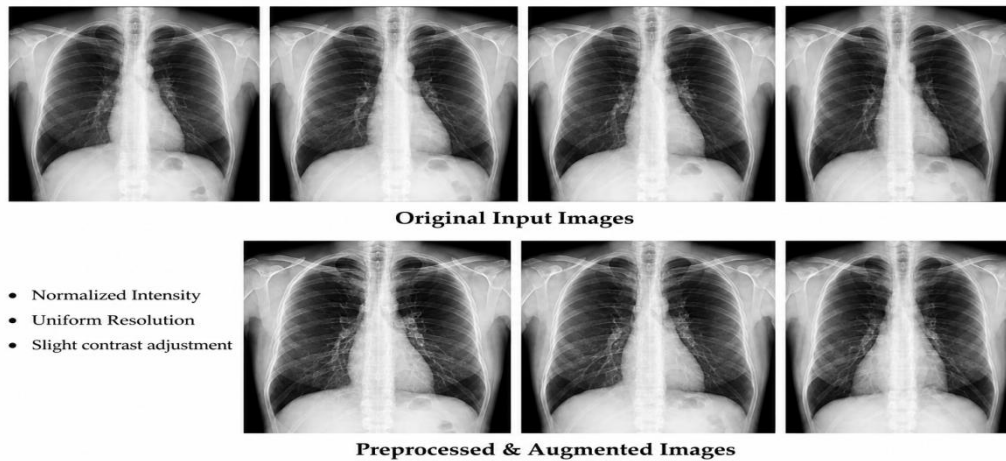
Sample chest x-ray images after preprocessing stages
